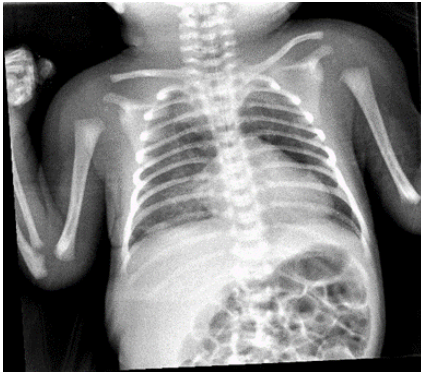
Pneumomediastinal air in chest X-ray and loculated air in thorax CT of the first patient
